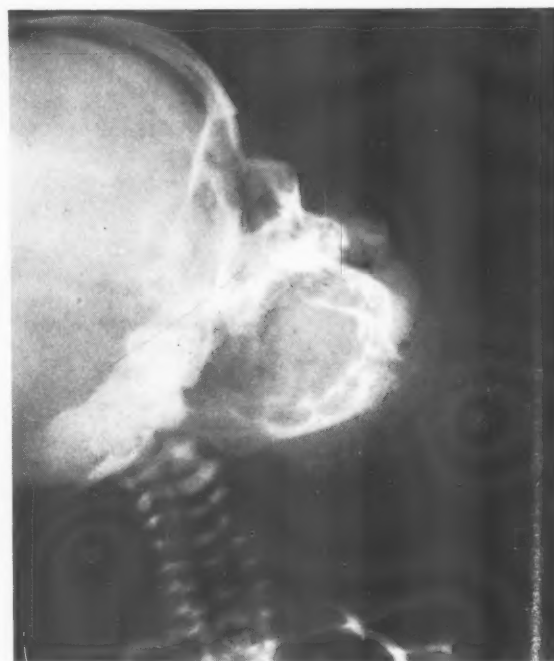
Case 2. Lateral radiograph showing calcification in tumour.
